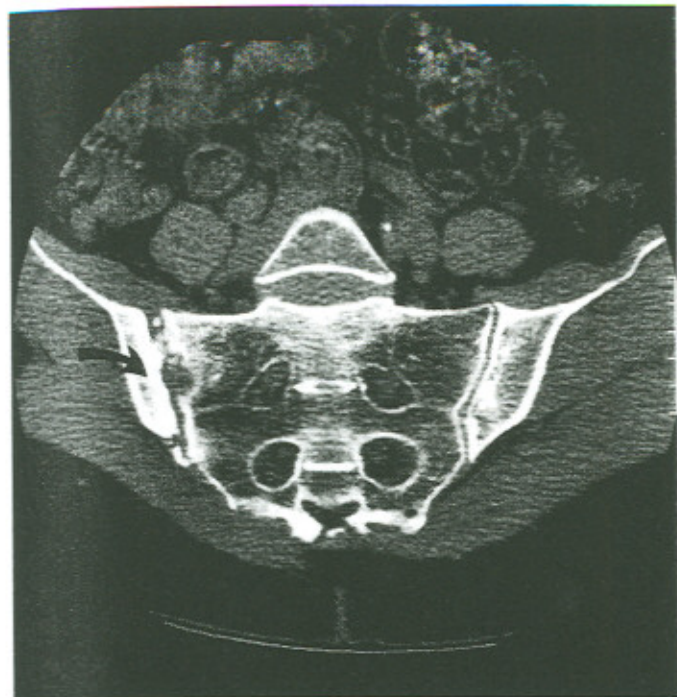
CT scan showing the sacroiliac joints of patient in case two, approximately 2 years after the onset of symptoms. There is extensive erosion of the margins of the left SI joint (arrow). Again, the right joint appears normal.
